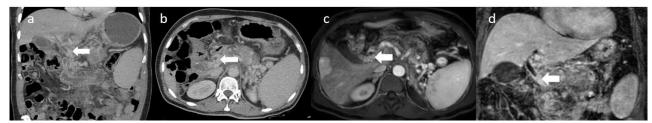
Coronal reformatted (a) and axial (b) Computed Tomography images show common bile duct wall thickening from dilated epicholedochal collaterals (arrow). Contrast-enhanced axial T1-weighted image (c) shows pericholecystic portacaval collaterals (arrow), and coronal T1-weighted image (d) shows distal bile duct compression (arrow) from dilated epicholedochal vessels.
